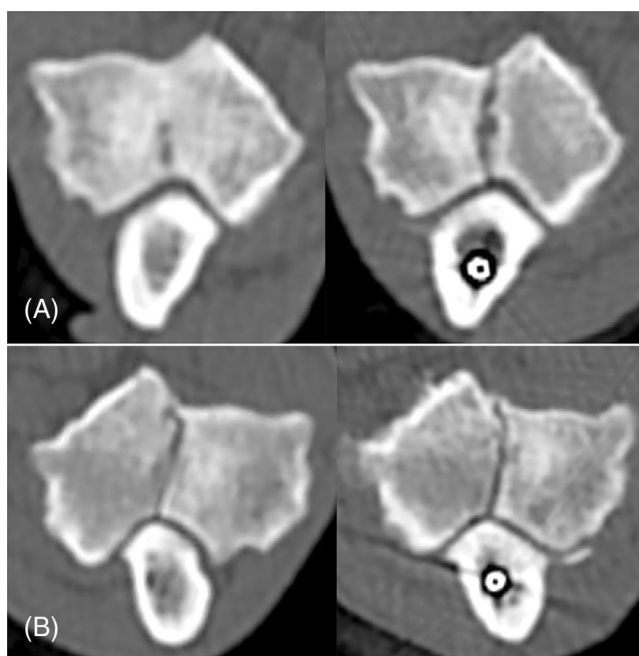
Example of poor/lack of healing of the fissure after performing an oblique proximal ulnar osteotomy (PUO) (left column: pre-operative computed tomographic (CT) images; right column: latest follow-up CT images). (A) A 3-year-old cocker spaniel (A2: 23-month follow-up). (B) A 6-year 5-month-old english springer spaniel (B2: 24-month follow-up).
